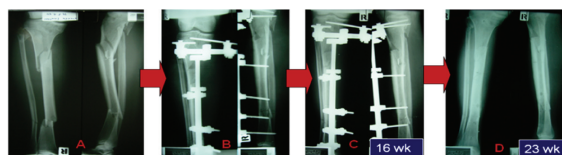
The radiographic of a patient with type IIIA
